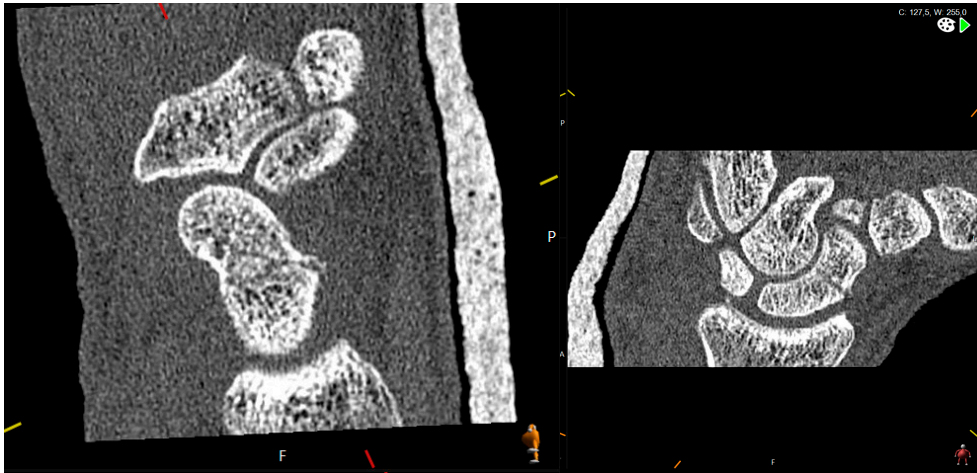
Reconstruction of CT images.
